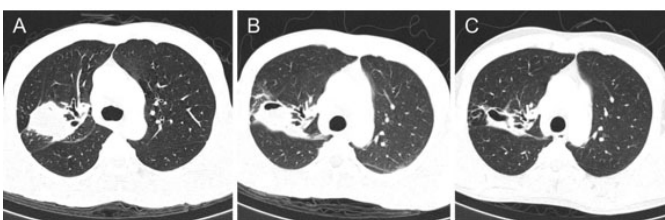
Series of CT thorax (axial view) in lung window at the same level showing (A) the right upper lobe mass on initial scan, (B) three months after the initial CT scan (mid therapy) showing reduction in the size of the mass with cavitation and air-fluid level within, and (C) after completion of anti-tubercular therapy showing resolution of the mass with residual traction bronchiectasis and calcifications.
